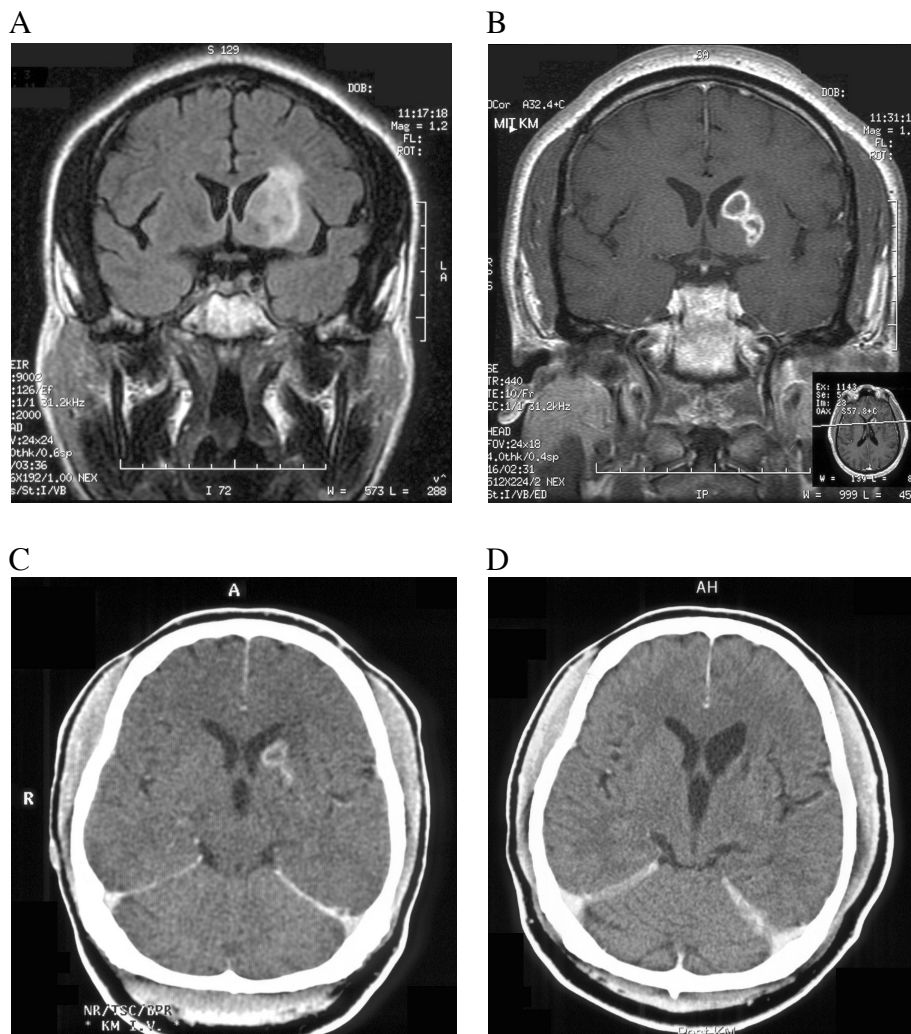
A-B. Initial MR T1-weighted image without (A) and with contrast injection (B). C: CT-scan with contrast injection 8 days later D: CT-scan with contrast injection 4 months later
